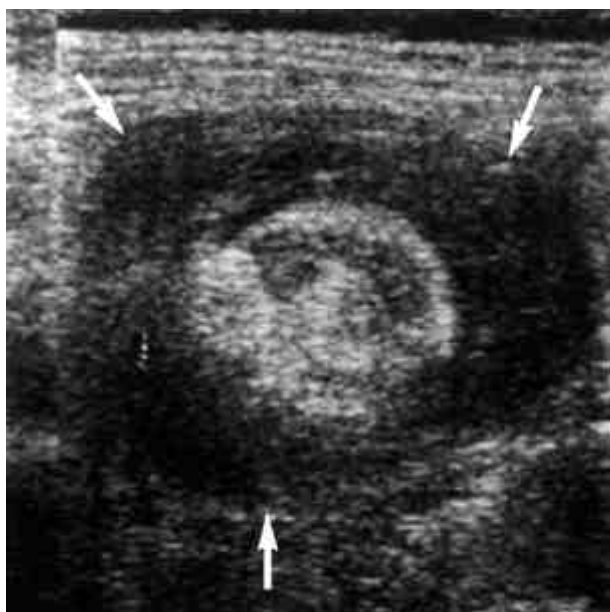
A 45-year-old man with ileocolic intussusception caused by a ileal lymphoma. Sonogram shows a round tumor with central echocomplex (arrows) mimicking "multilayered target".
